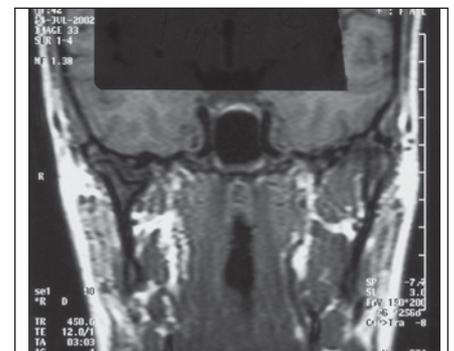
(right) Magnetic resonance image, coronal view, 7 years after treatment, corroborates findings shown in Fig 5.
